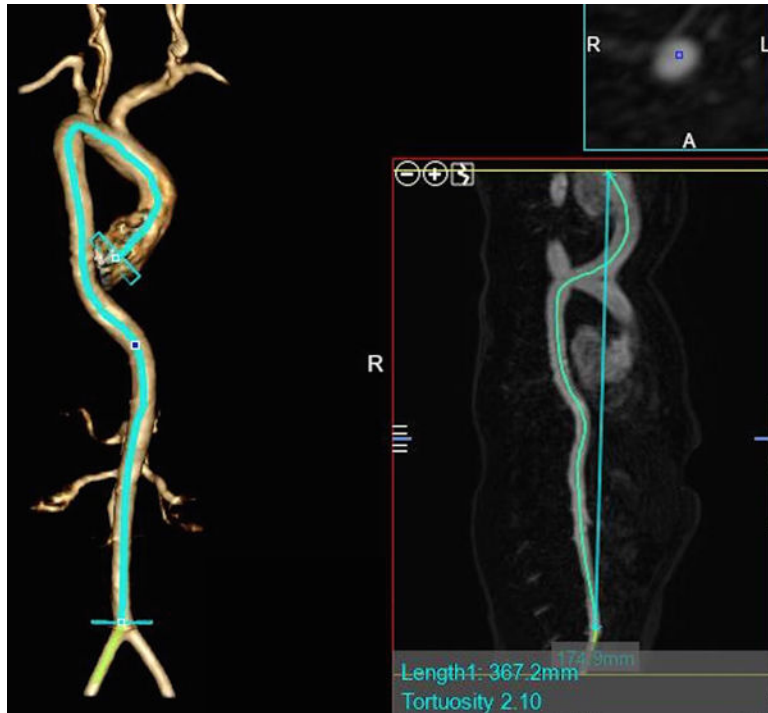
Calculating the aortic tortuosity index (ATI), per Franken et al., International Journal of Cardiology 2015²⁹ from a 3D computed tomography angiogram. ATI is calculated as the ratio of aortic length (actual length) to geometric length (straight length). The aortic length (left side of image) was defined as the length of a centerline through the entire aorta (from annulus to aortic bifurcation) created by manually placed seeding points through the lumen of the aorta using post-processing software. Geometric length is the Cartesian distance between its 2 endpoints (added in smaller image on right, overlying the centerline). Aortic tortuosity index (ATI) is measured by dividing aortic length by geometric length. In this example in a patient with significant aortic tortuosity, aortic length = 367.2 mm, geometric length = 174.9 mm, ATI = 2.10. Images complements of Alex Dodd, Texas Children’s Hospital.
